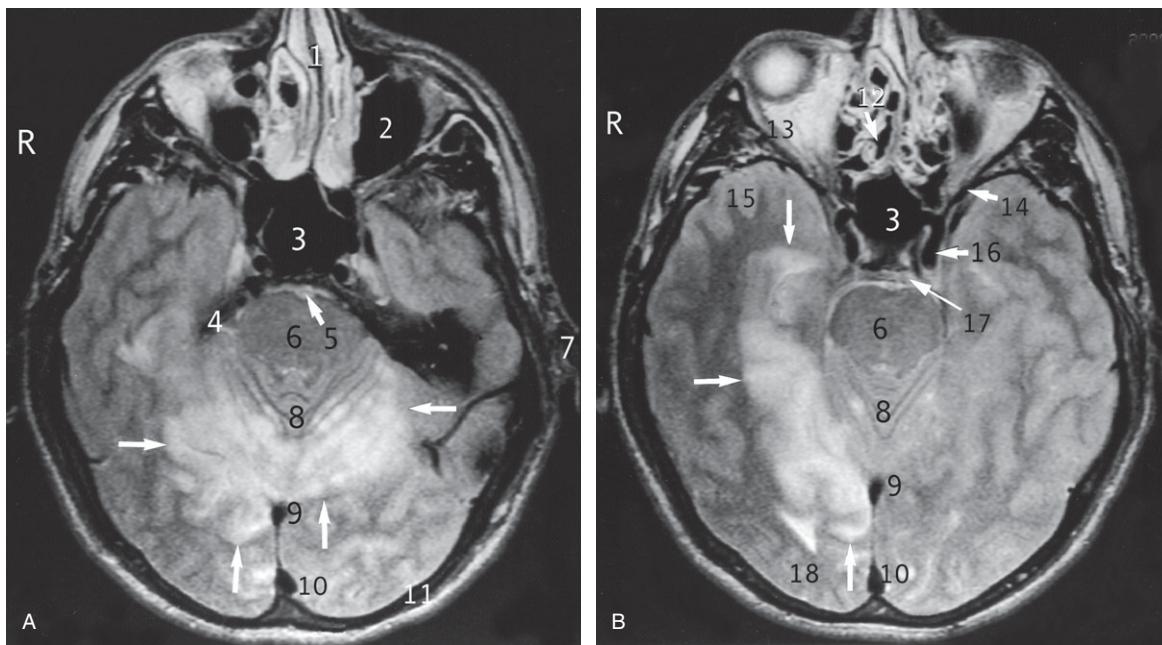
(A and B) MRA brain axial T2-weighted images. Arrows without numbers show parts of the brain with abnormal signals.
